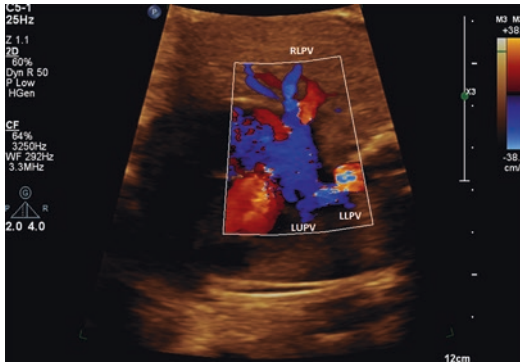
Color Doppler evaluation of the normal pulmonary venous connections (left). PW Doppler interrogation is the best when the line of acquisition is parallel to the vessel of interest, the left lower pulmonary vein in this case (right). Using a Philips Epiq machine with a C5–1 MHz curvilinear probe
